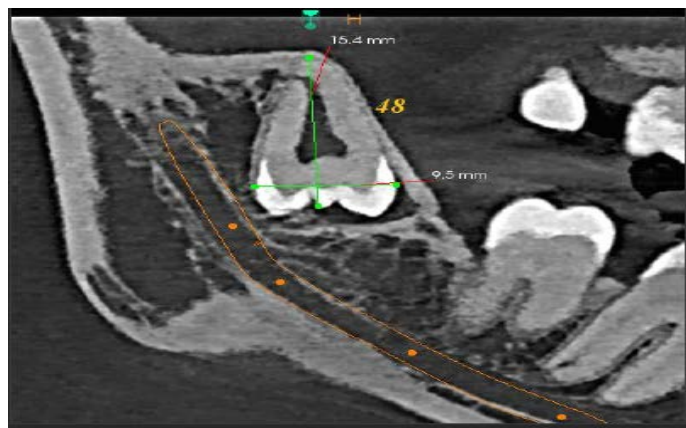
CBCT Measurements of Right Third Molar
